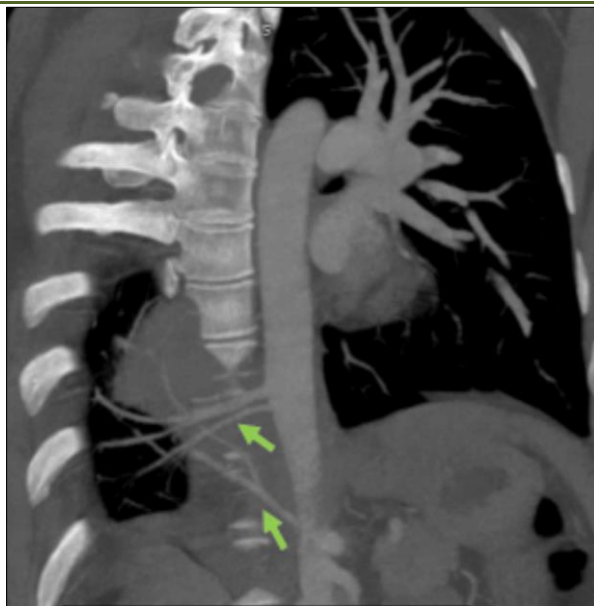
Adjusted coronal image with MIP of a chest CT-Angiography showing the systemic branches arising directly from the thoracic and abdominal aorta, and vascularizing the inferior right lobe (green arrows)
